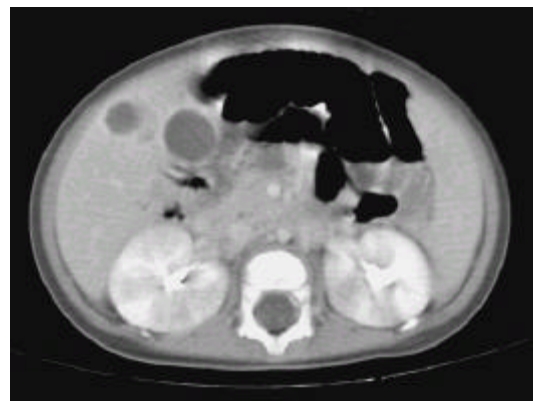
Abdominal CT showing about three focal abscess with enhancing walls in the right lobe of the liver, measuring 2.2 x 1.6 cm in segment 5 and focal small low attenuated lesion indicating renal abscess(Hospitalization day 7).
